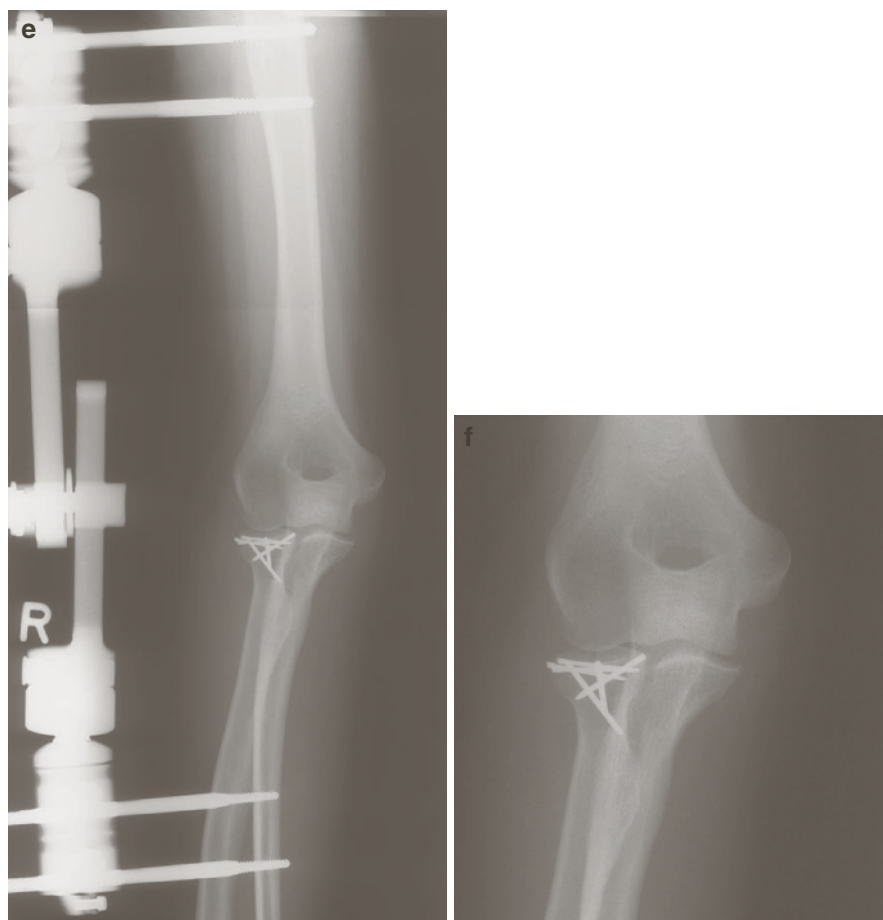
Twenty-three-year-old patient with complex fracture-dislocation of the right elbow with a comminuted fracture of the proximal radius; (a) X-rays in a cast after reduction; (b) Scout CT scan showing the “superman position.” (c) exemplary CT scans showing the extent of the radial head destruction; (d) 3-D
